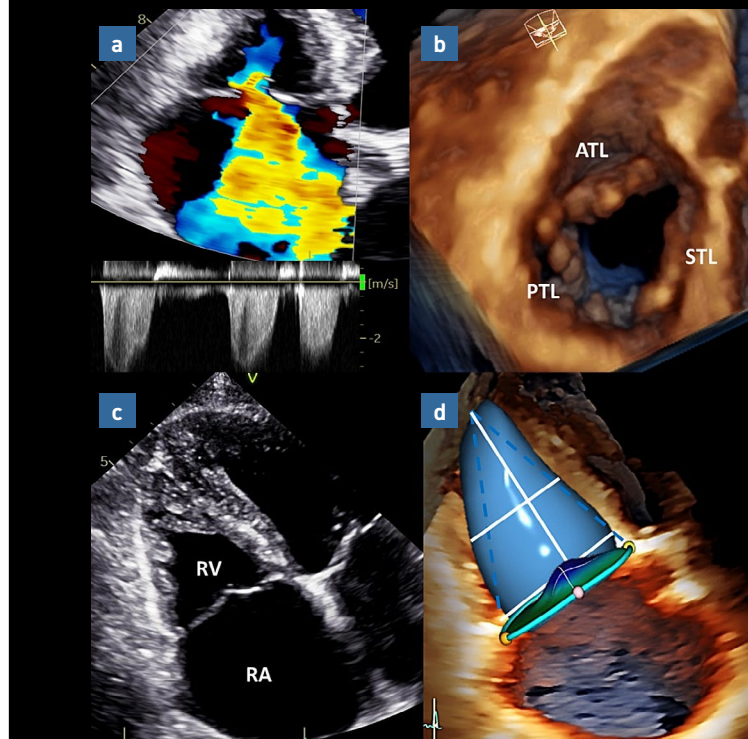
Patient with primary TR. An 82-year-old woman with arterial hypertension and a history of mitral valve prolapse presents with massive TR (EROA  $0.61 \text{ cm}^2$ ). The leaflets present excessive motion with suspected spontaneous chordae rupture(\*) (panel b). Three-dimensional echocardiography confirmed extensive prolapse of the leaflets in Barlow's disease, primarily involving the septal and posterior leaflets (panel c).
